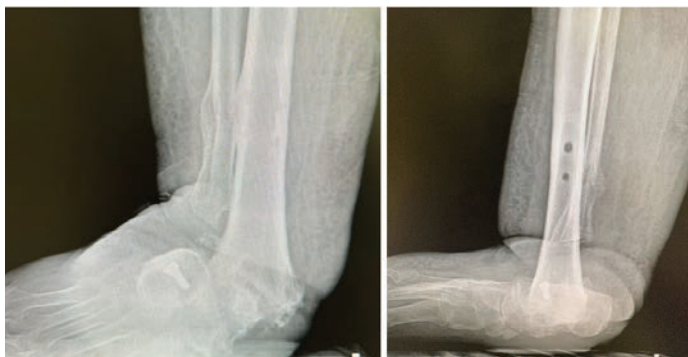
Radiographs demonstrating severe ankle deformity.
